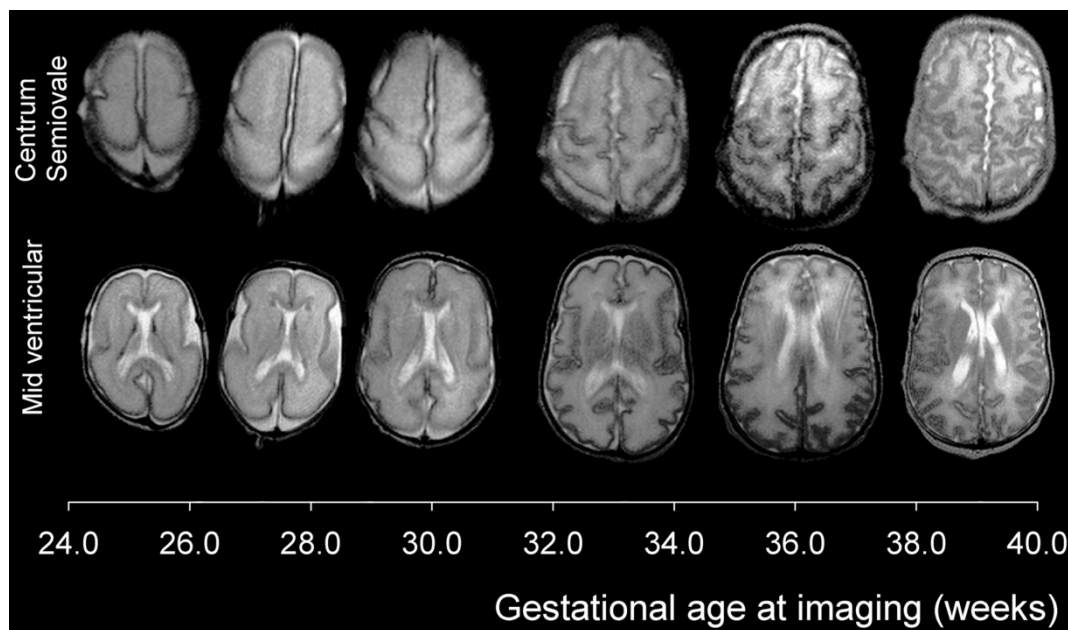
Increasing cortical complexity with age. Serial T_2 -weighted MRI acquired from a preterm infant born at 25 weeks gestation. Axial slices are shown at the mid-ventricular level (bottom row) and the level of the centrum semiovale (top row) between birth and term-equivalent age. Image modified from Figure 2 in Kapellou et al. (2006).
